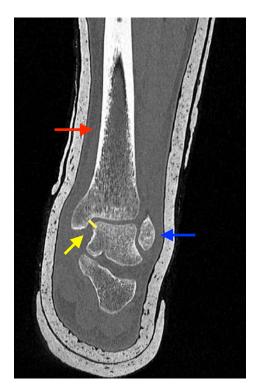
Computed tomography scan of the left ankle and the distal part of the lower leg in anterior view (preoperative) The anterior view visualised the tibia medially (indicated by red arrow) and the lateral malleolus of the fibula (indicated by blue arrow). An increased medial clear space (indicated by a yellow arrow) can be observed.
